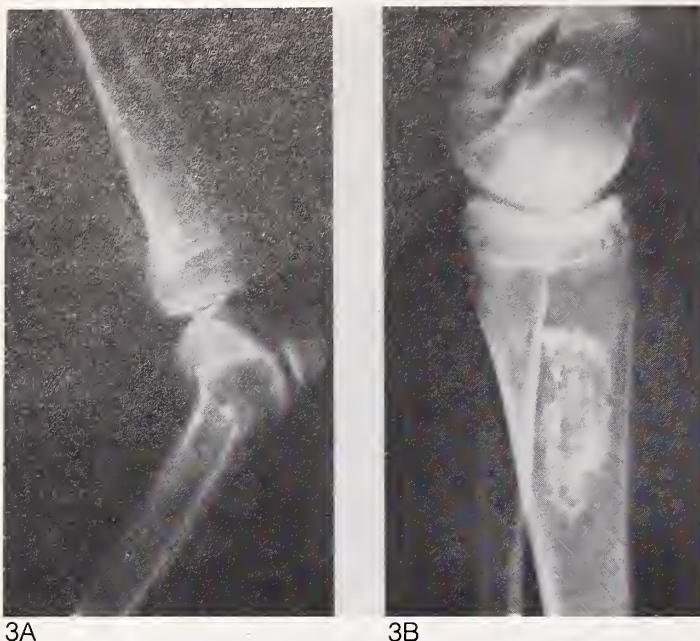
Roentgenographic appearance of dysbaric osteonecrosis, "caisson disease" (reproduced with permission²). A: Involving the head of the tibia. B: Involving the distal femur.
